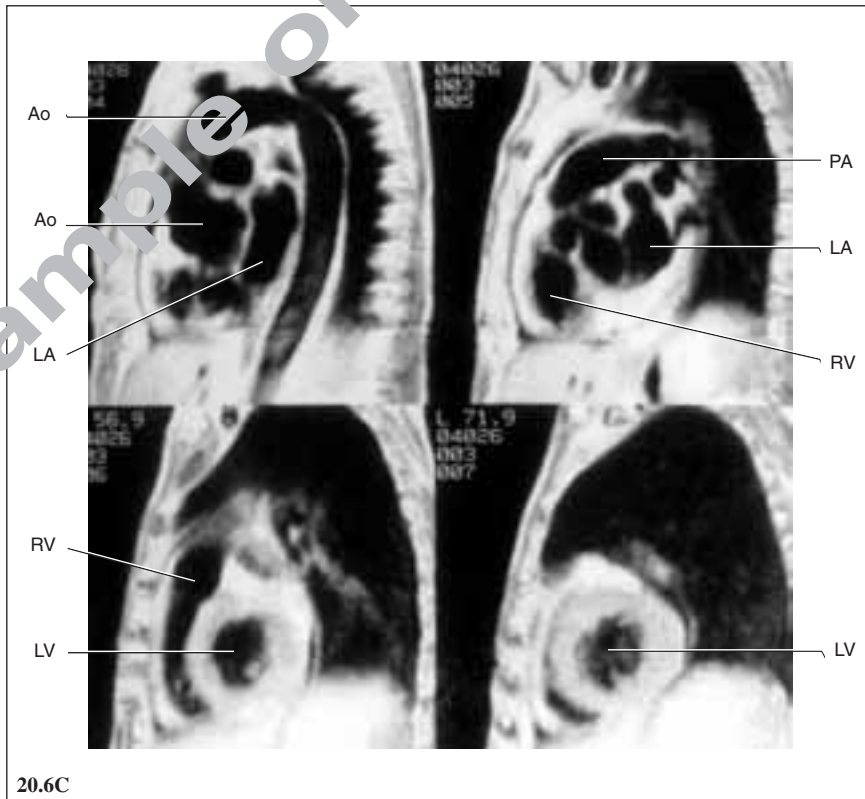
Normal MR images of the heart. (A) Axial plane. (B) Coronal plane. (C) Sagittal plane. (Key: SVC: superior vena cava, IVC: inferior vena cava, RA: right atrium, RV: right ventricle, PA: pulmonary artery, LA: left atrium, LAA: left atrial appendage, LV: left ventricle, AA: ascending aorta).
